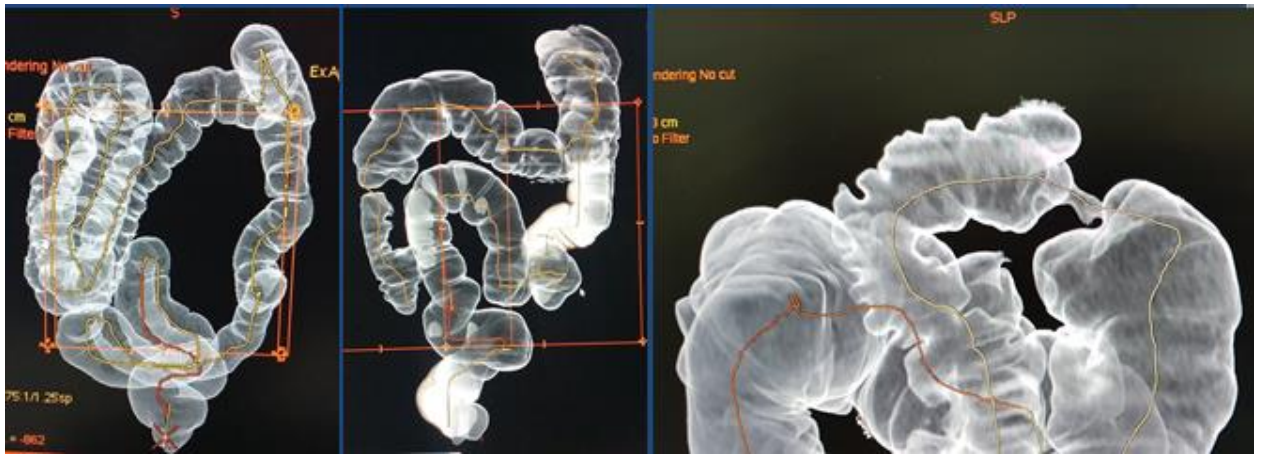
CT colonography: 3D aerogram (dolichocolon, exophytic cancer, endophytic cancer)
